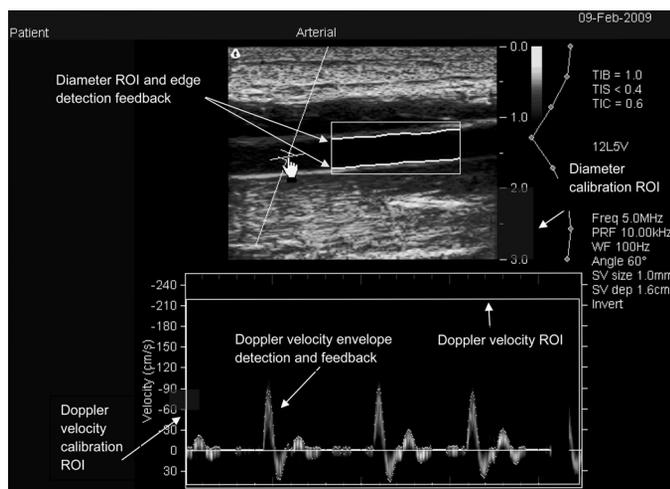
Still frame of B-mode ultrasound image acquisition software. The calibrate diameter, calibrate Doppler, diameter, and Doppler regions of interest (ROIs) are highlighted. Diameter is calculated using a parallel-prong rake algorithm of 200 to 300 parallel lines within the ROI at 30 Hz. Velocity is calculated via grayscale filtering using an automatic thresholding algorithm with subsequent binary interrogation of each pixel column to detect the waveform envelope. The diameter and velocity output data, at 30 Hz, are displayed for visual feedback purposes.
